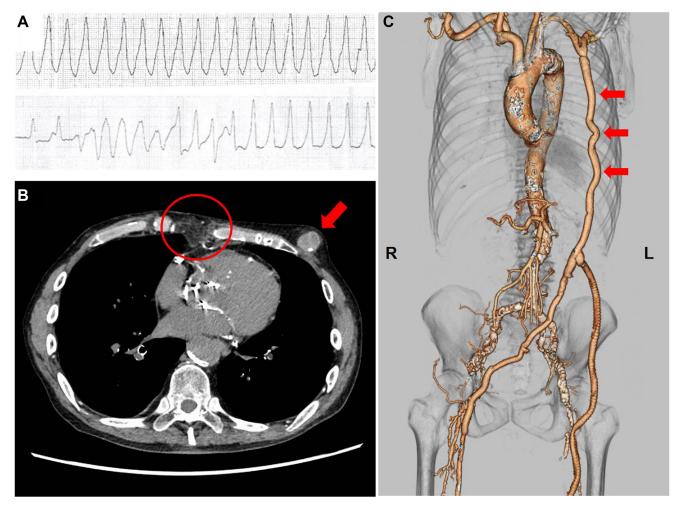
A: Upper panel: ventricular tachycardia recorded by an ambulatory monitor. Lower panel: the initiation of a recurrence after admission. B: Postoperative computed tomography scan in the short-axis view depicting the defective sternum refilled by the omental flap, as highlighted by the red circle, and prosthetic graft, shown by the red arrow. C: Three-dimensional reconstruction of the major arteries revealing the axillary femoral bypass graft appearing in the left first intercostal space and located along the midclavicular line (*red arrows*).
